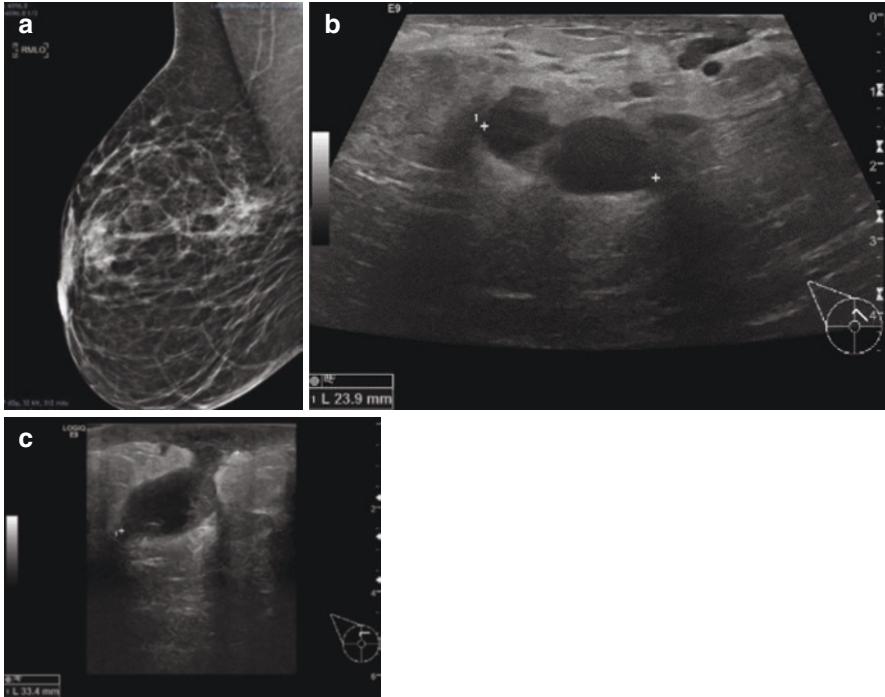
(a) A 51-year-old woman with granulomatous mastitis. Mammograms show a right retroareolar ill-defined mass with a more posterior ill-defined asymmetry. (b) Ultrasound showing two focal inflammatory collections. (c) Retroareolar collection extending into the skin surface
